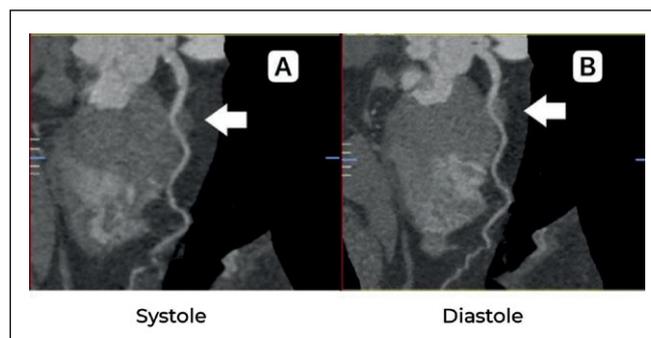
A tunneled fragment and a pronounced myocardial bridge (arrows) in the systole (A) and diastole (B) in the proximal segment of the LAD (CT angiography of the coronary arteries).
